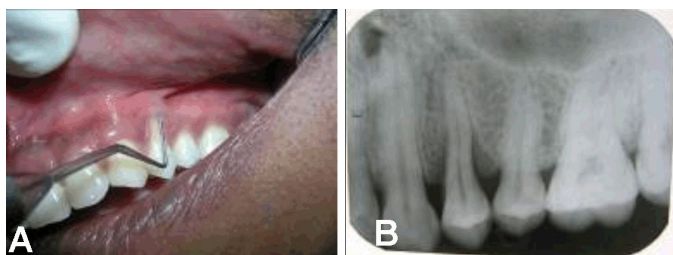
(A) Miller's Class III recession of 24, (B) Radiograph showing periapical lesion and infrabony defect at distal aspect.
